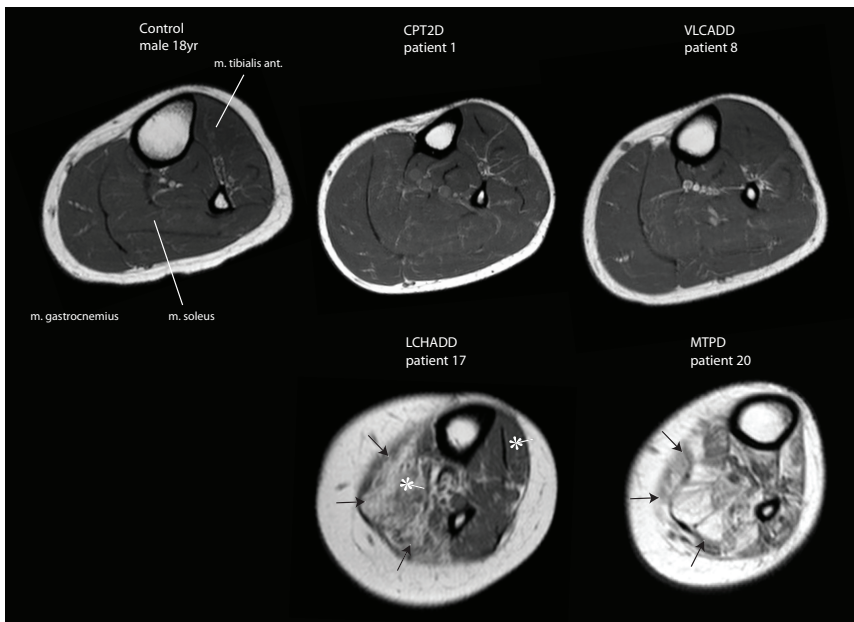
T1-weighted images of lower left leg. T1-weighted transversal images of the lower left leg in control and CPT2D, VLCADD, LCHADD and MTPD patients. Black arrows indicate high signal intensity in the muscles (LCHADD and MTPD). The asterisk emphasizes the difference in signal intensity between m. gastrocnemius and m. tibialis.
